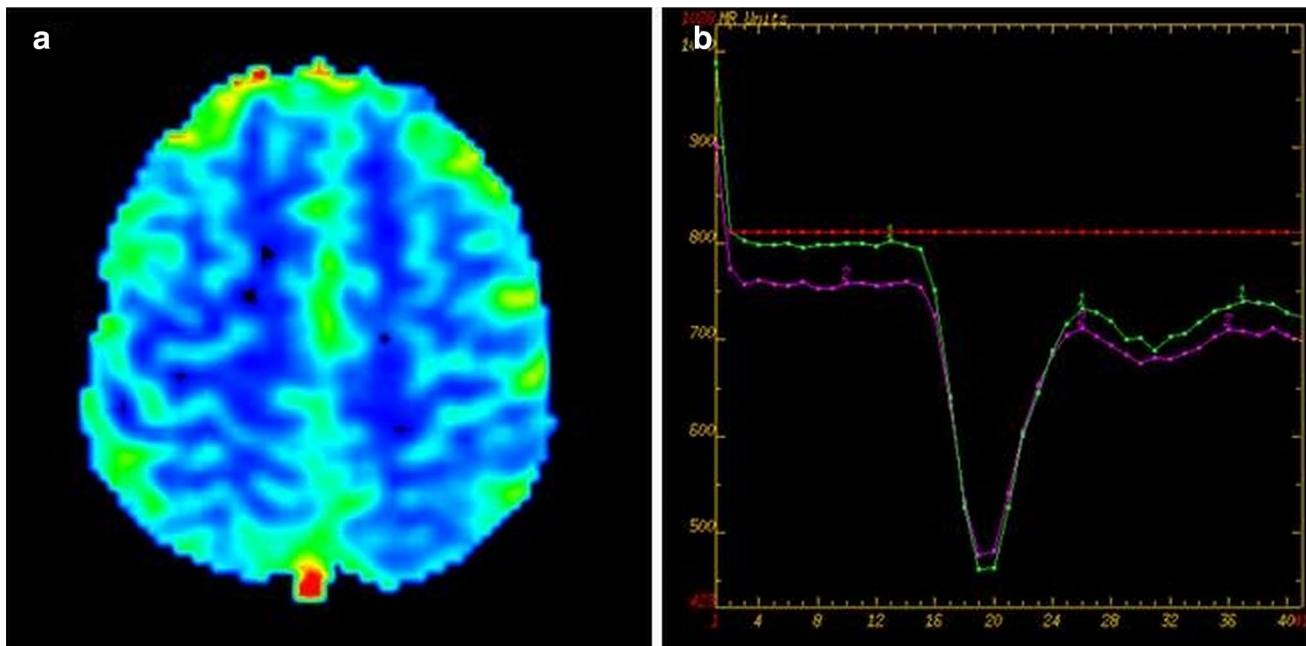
DSC perfusion MR images of a 21-year-old male patient who had epilepsy. a A clear perfusion increase was not observed on colored rCBV map of lesion area. b Perfusion dynamic of the lesion was similar to that of normal parenchyma on perfusion graph
